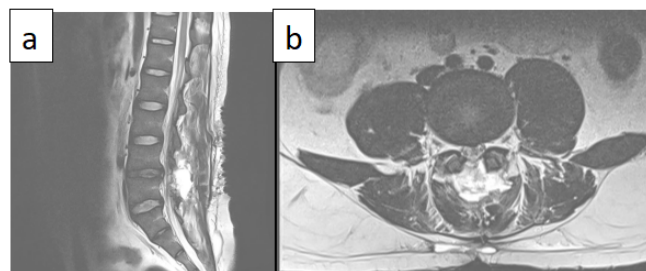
Post Operative MRI-Images a) T2 weighted sagittal image showing resolve of giant pseudomeningocele, hyperintensity of fibrin glue implies no communication with dura b) T2 weighted axial image showing post operative changes with some hyperintensity signals of fibrin glue over the dura repair site.
